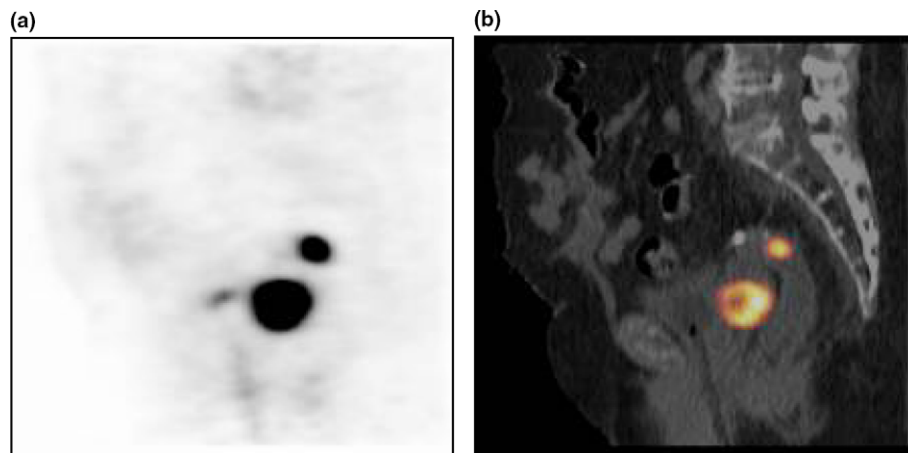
Sagittal images from a combined or hybrid computerised tomographic/positron emission tomographic (CT/PET) scanner. (a) A PET scan showing marked [^{18}F]-fluorodeoxyglucose (FDG) uptake in a verified cervical tumour and a pre-sacral focus consistent with a metastatic deposit. The concomitant CT scan did not demonstrate a pathologically enlarged lymph node in this location. (b) This image demonstrates a fused CT and PET image that localises the presacral uptake from the PET scan onto the CT scan indicating metastatic spread to a regional lymph node. Such methods of combining anatomical details with biological tumour information are likely to improve staging accuracy and aid target definition for radiotherapy planning in the future. (With the kind permission of CTI Molecular Imaging.)
